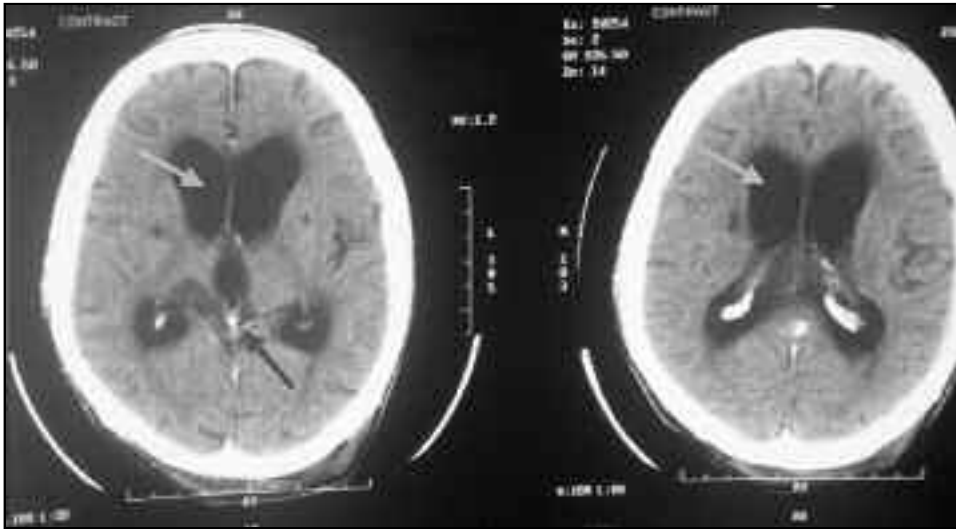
Contrast CT brain of the patient shows hydrocephalus. White arrow shows dilated lateral ventricles and red arrow shows prominent fourth ventricle.
